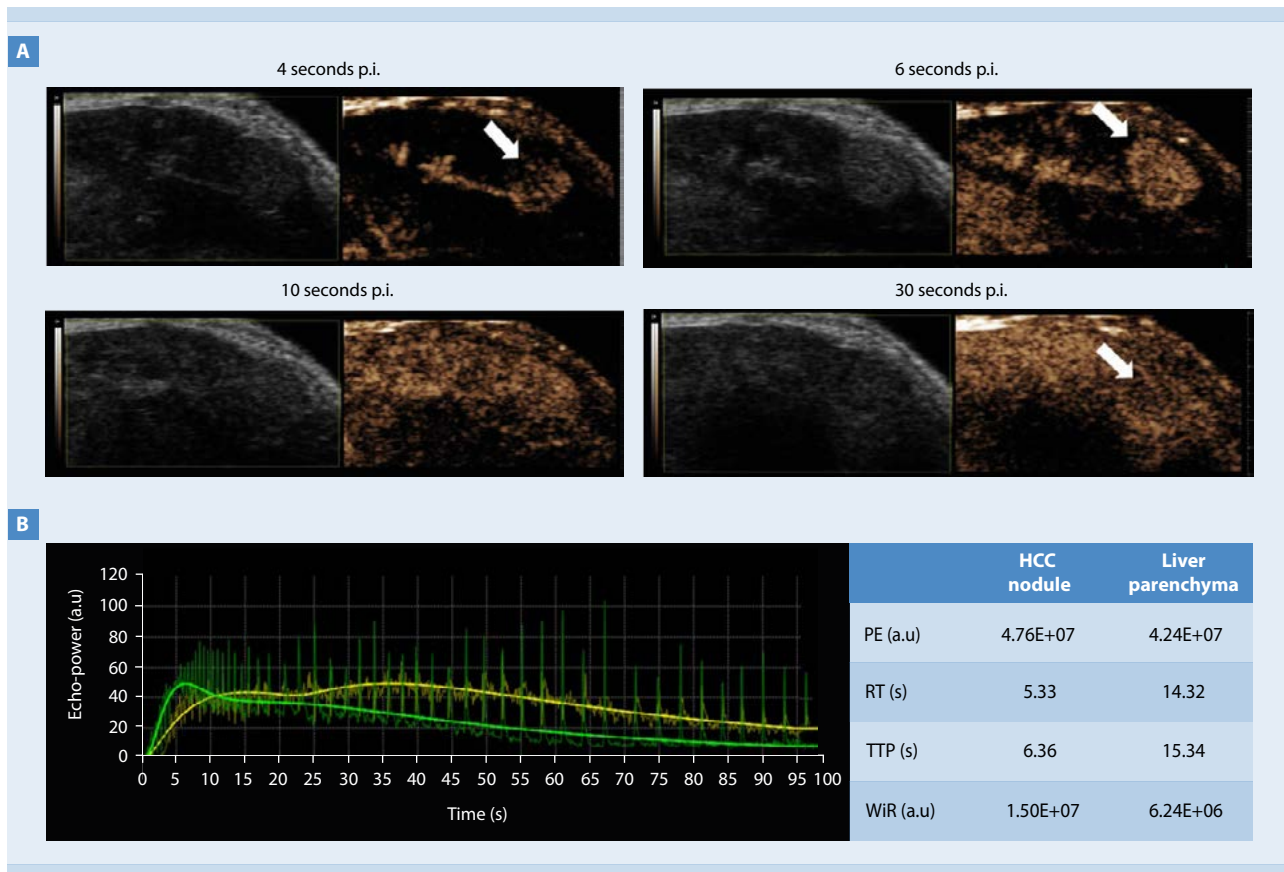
Visualization of the typical wash-in/wash-out pattern of HCC nodule enhancement over a period of 100 s post injection (p.i.) of PolySon L. A. Side-by-side displays of B-mode (left) and CEUS (right) images at selected timepoints showing rapid hyperenhancement in the wash-in phase, followed by hypoenhancement in the wash-out phase. The white arrows on the CEUS images point to the liver lesion. B. Time-course of the ultrasound signal intensity in the HCC nodule (green) and surrounding liver parenchyma (yellow), and corresponding kinetic parameters (peak enhancement, PE; rise time, RT; time to peak; TTP and wash-in rate; WiR) proving the presence of moderately differentiated HCC.
